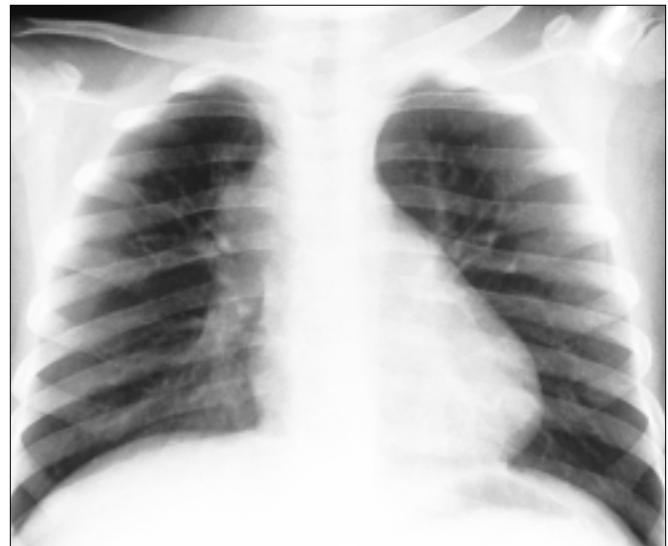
Posteroanterior chest radiograph shows right paratracheal adenopathy and a small round density in the right upper lobe.
